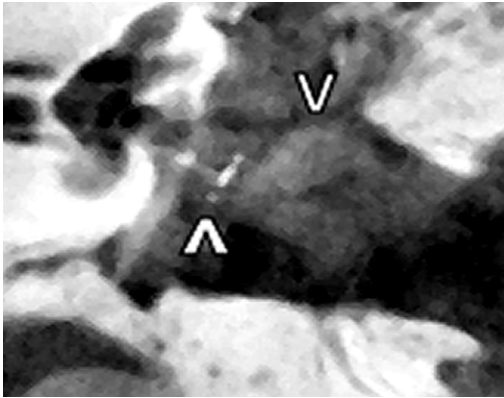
The postoperative situation after tympanoplasty with titanium PORP, CWD procedure, and posterior EAC wall reconstruction imaged by CBCT (V); coronal view. In addition to bone chips and paté, PLGA plates have been used in the reconstruction. Thick arrowhead: PORP; thin arrowhead: site of the canal wall reconstruction.
